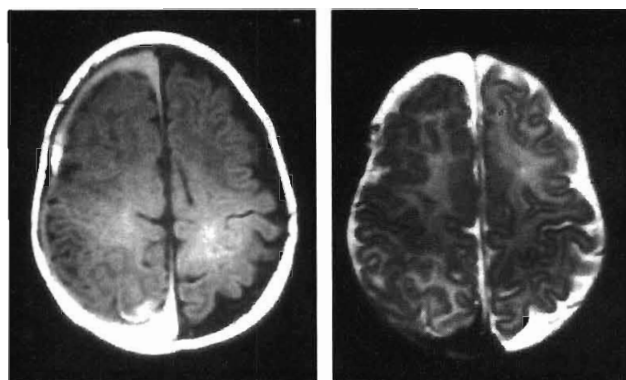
Nonaccidental head injury. Axial T1- (A) and T2-weighted (B) MRI scans of an infant reveal bilateral subdural blood collections of different ages. The right collection shows blood in the late subacute phase (2 to 4 weeks old), and the left shows blood in the chronic phase (>1 month). This finding is almost proof positive of repeated abuse.
